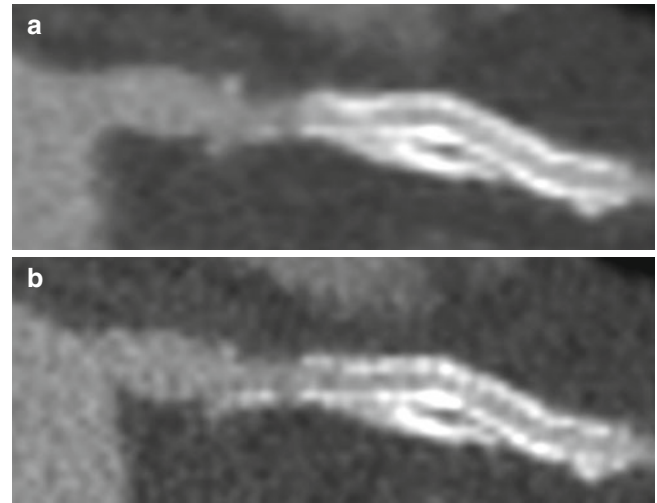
Effect of high spatial resolution mode on image quality. Curved planar CT image of sirolimus-eluting stent (Cypher) with standard mode (GE, Discovery 750) (a) and high-definition mode (b). In the high-definition mode image, blooming artifact from stent strut and calcified plaque was markedly reduced as compared with that of standard mode
